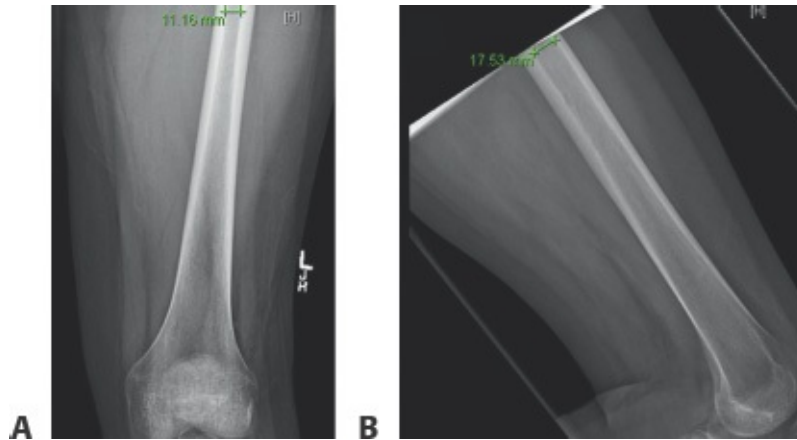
• A,B. Preoperative radiographs of the donor femur. The inner diameter of the isthmus is used to determine the reamer head size needed for bone graft harvest.
